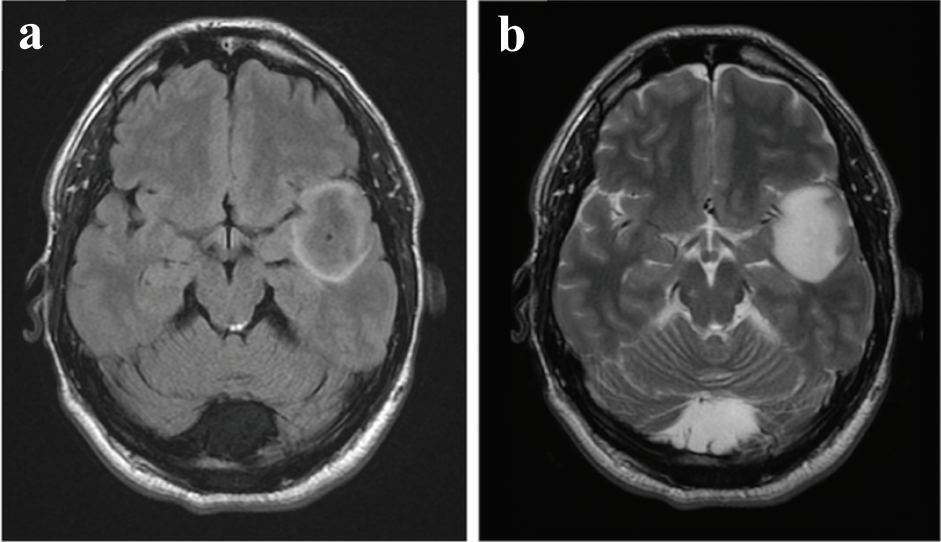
MRI scan of IDH-mutated astrocytoma with the T2-FLAIR mismatch sign. 3a: FLAIR sequence with hyperintense peripheral ring and hypointense center. 3b: T2W sequence showing a homogeneous hyperintense signal. From Corell and colleagues, The clinical significance of the T2-FLAIR mismatch sign in grade II and III gliomas: a population-based study, Supplementary material, BMC Cancer 2020.
